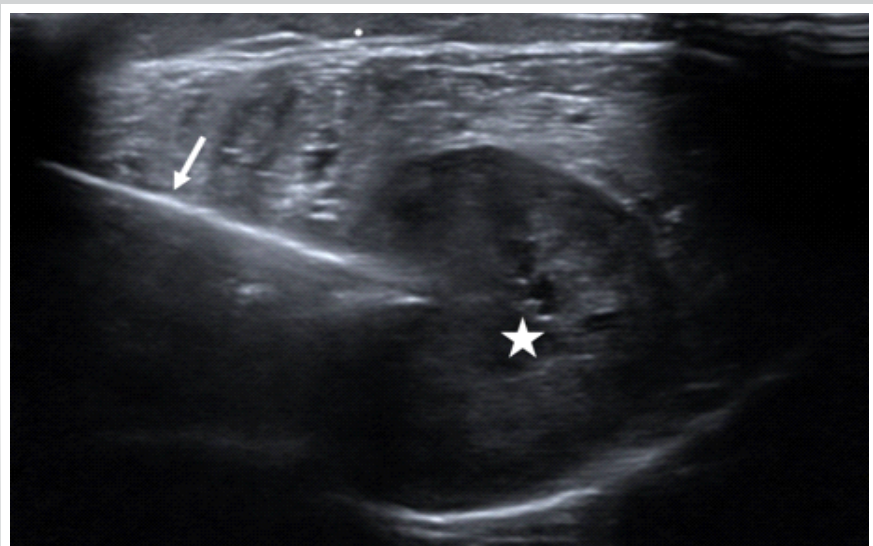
Ultrasound image demonstrating ultrasound-guided core needle biopsy of the lesion. (Arrow: Biopsy needle, Asterisk: Lesion).
